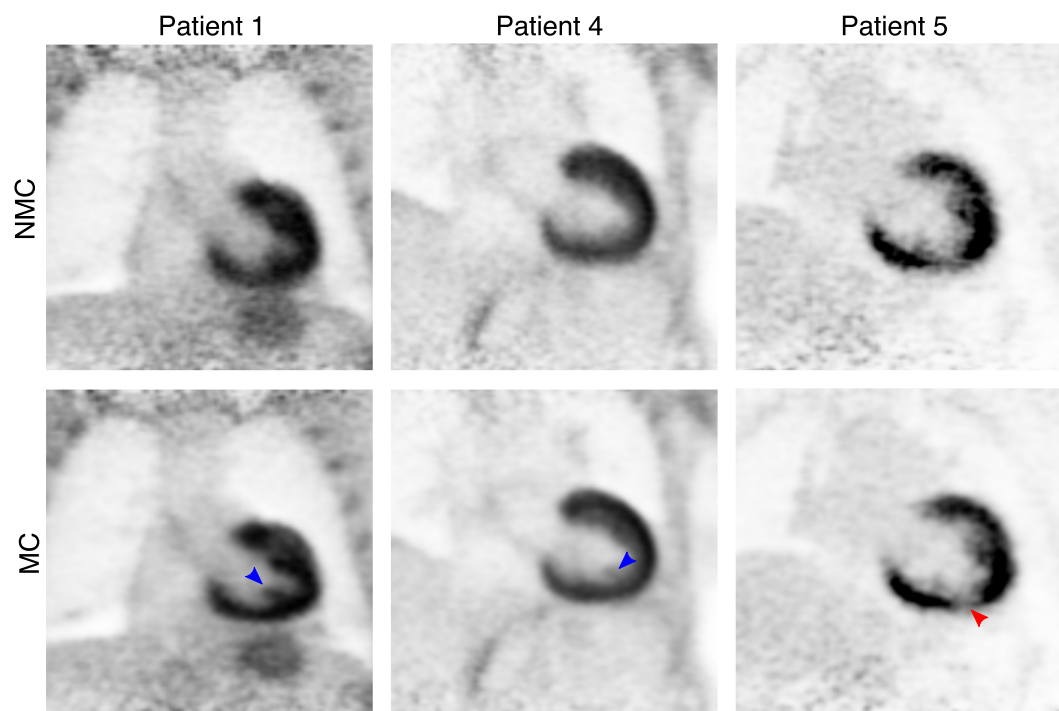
Coronal slice for 3 representative patients (columns) showing uncorrected (NMC) and motion-corrected (MC) viability ^{18}F -FDG PET images. Improvements in image quality can be observed when applying MC, particularly in small structures (blue and red arrows), compared to NMC.
